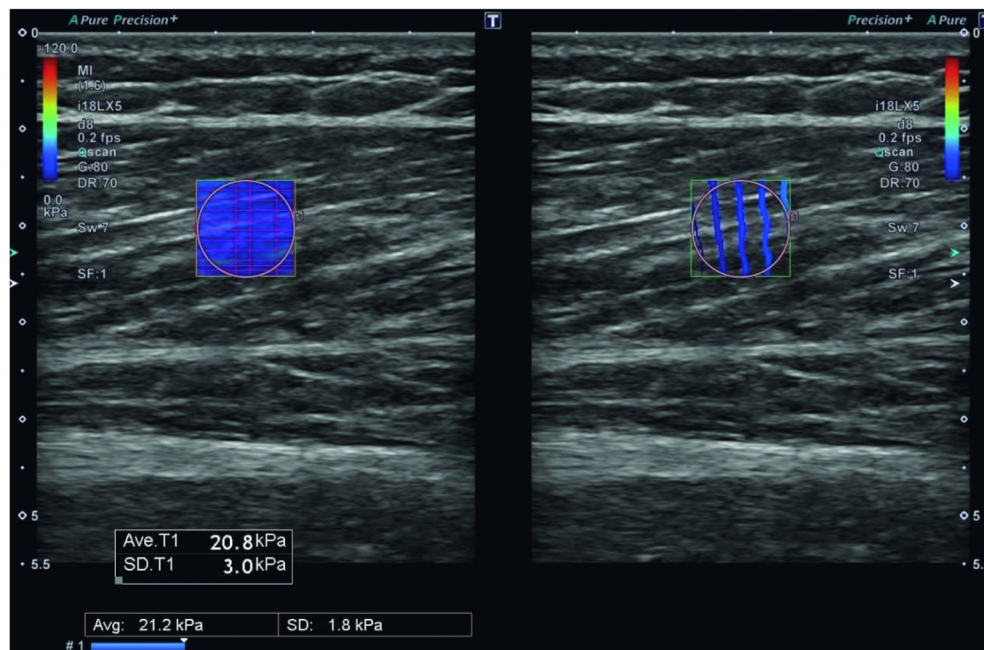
Example of a biceps femoris long head passive muscle stiffness measurement via ultrasound-based shear-wave elastography. A 10-mm elastogram was taken from the central region of the biceps femoris longhead muscle belly.
